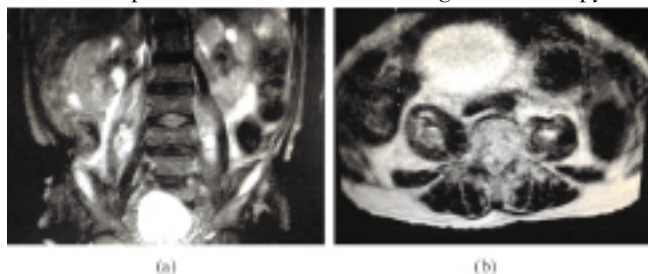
A magnetic resonance imaging (MRI) scan of the abdomen and pelvis revealed bilateral iliopsoas hematomas.
